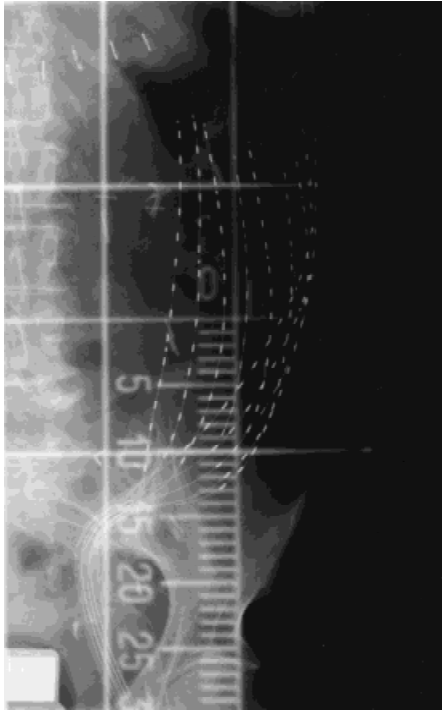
Radiograph of a mesh implant for a retroperitoneal sarcoma (as described in the reported case, Patient No. 3).
